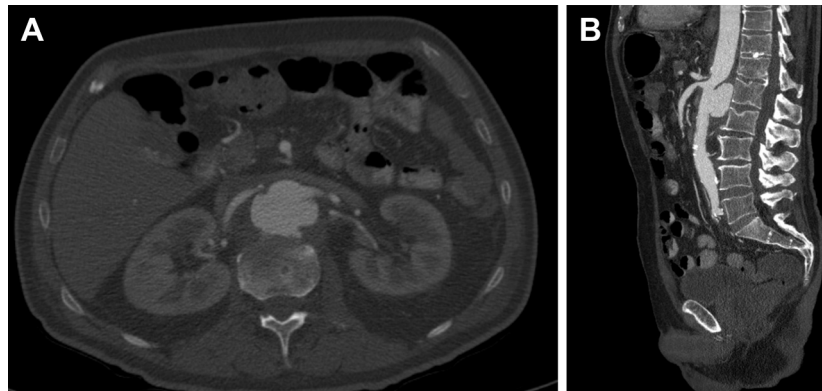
A and B, A computed tomography (CT) angiography shows an aneurysm with a contained rupture at the level of the visceral arteries.
